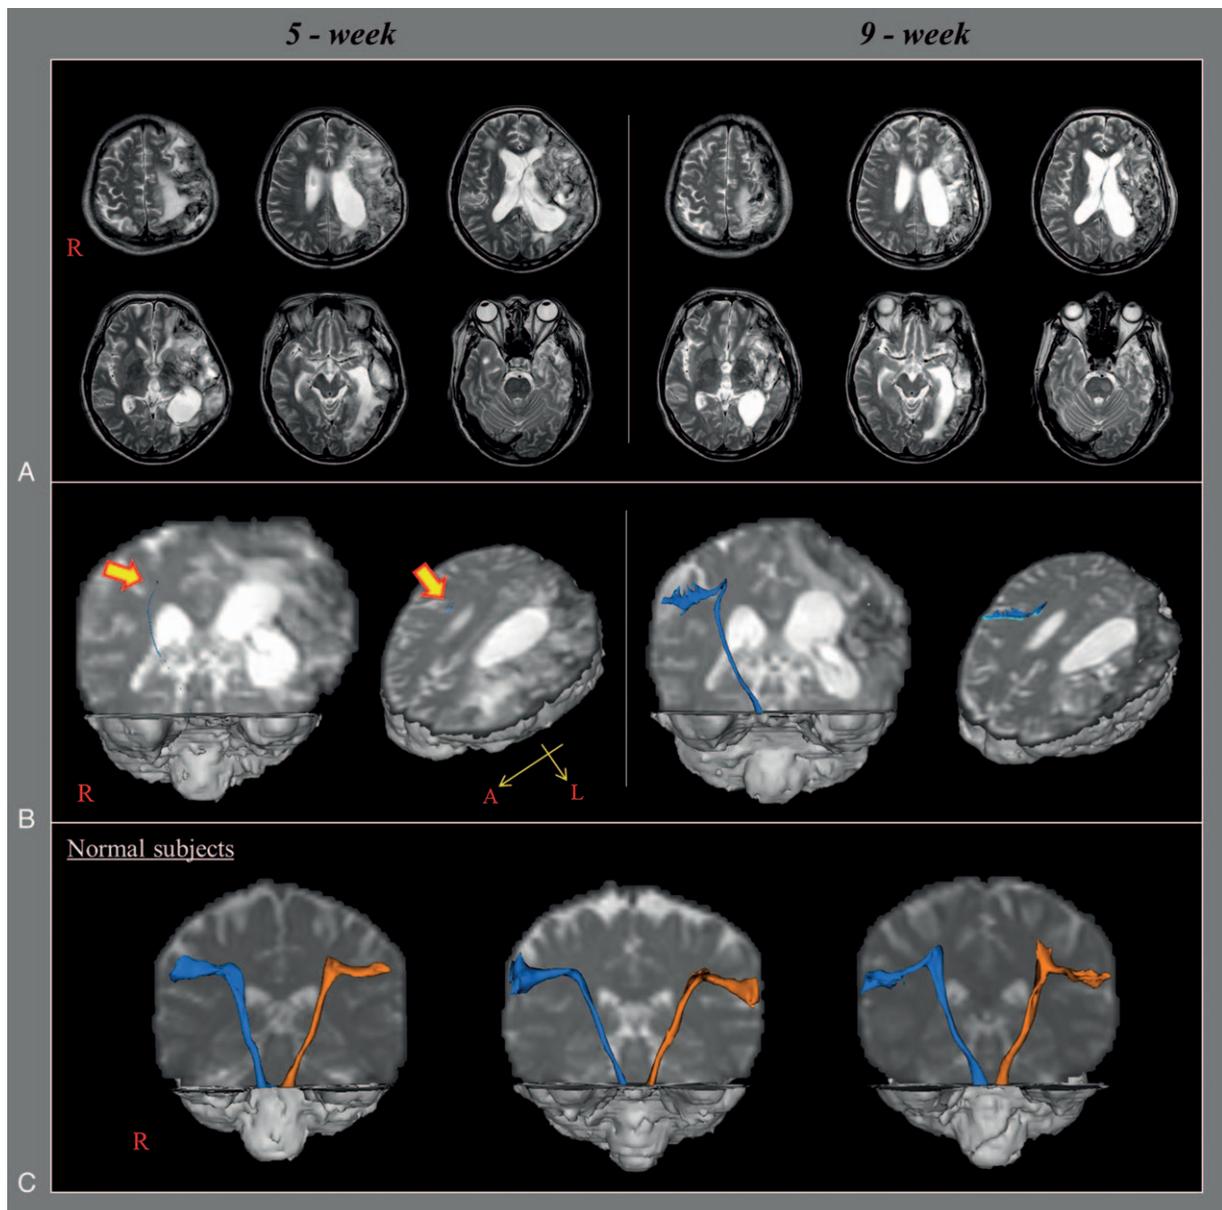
(A) T2-weighted brain magnetic resonance (MR) images at 5 and 9 weeks after onset show leukomalactic lesions in left middle cerebral artery territory. (B) Diffusion tensor tractography (DTT) for the corticobulbar tract (CBT). On 5-week DTT, the right CBT is discontinued at the subcortical white matter and shows severe narrowing compared with those of normal subjects, whereas the left CBT is not reconstructed. By contrast, on 9-week DTT, the right CBT is extended to the cerebral cortex with thickening, whereas the left CBT is still not reconstructed. (C) Reconstructed CBT of normal subjects (55-year-old man, 57-year-old man, and 60-year-old man).
